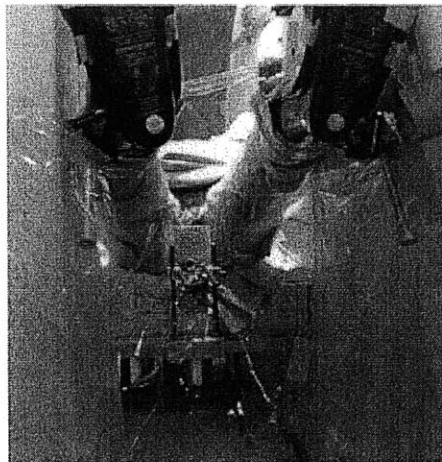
MR images are captured using a large magnet as shown in (a). Different sequences highlight different tissues, as shown in images (b) of T1-weighted MR, (c) of T2-weighted MR, and (d), of SPGR sequence MR. T1- and T2-weighted images produce superior soft tissue differentiation but poor seed differentiation, while SPGR sequences resolve seeds as black signal voids but do not differentiate soft tissue well. These three MR scans were taken in one session, less than an hour long, without moving the patient between scans. The consistency in patient positioning throughout these three scans introduces the possibility of easily registering these images to achieve MR's promised soft tissue differentiation with suggested seed positions.
